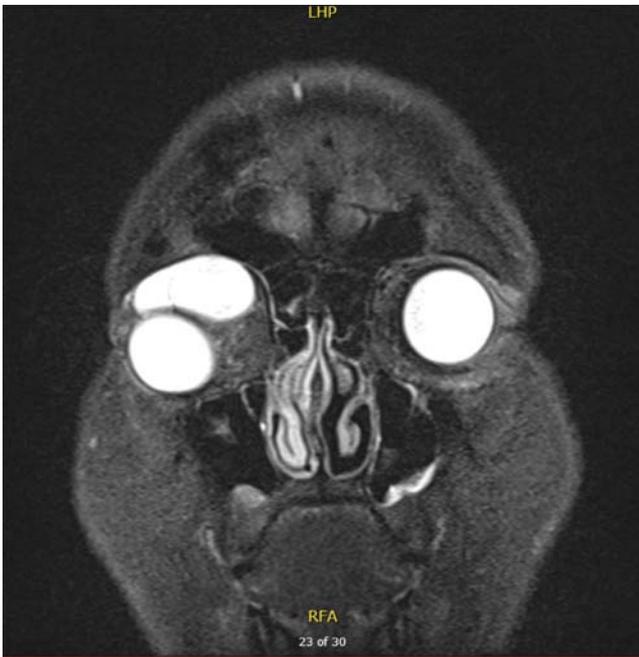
T2-weighted, coronal-cut magnetic resonance imaging demonstrating a $5.1 \times 3.3 \times 2.4$ cm cystic mass affecting the optic canal continuous with the right superior orbit and right frontal extra-axial space, an effaced right superior muscle complex, mass effect and proptosis of the right globe, and crowding of the right orbital apex.
